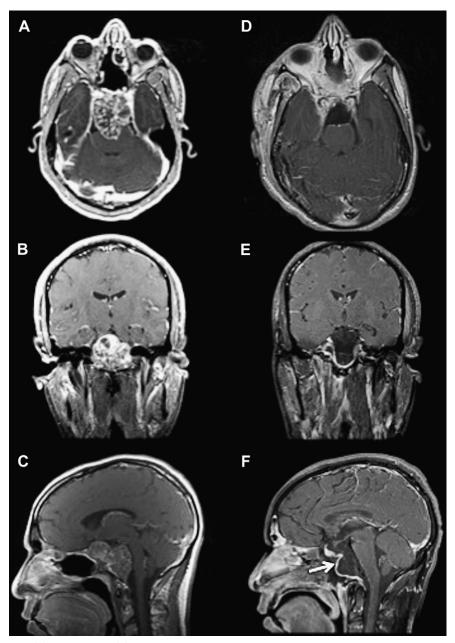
(*A*) Axial, (*B*) coronal, and (*C*) sagittal preoperative magnetic resonance images showing a large recurrent clival chordoma in a 27-year-old male patient. This heterogeneously hyperintense lesion involves the entire clival area, with posterior dislocation of the pons, lateral extension up to both petrous apexes, and invasion of the cavernous sinuses. (*D*) Axial, (*E*) coronal, and (*F*) sagittal postoperative magnetic resonance images after an endoscopic endonasal approach to the clival area, demonstrating the complete removal of the lesion. The arrow shows the enhancing nasoseptal flap that has been used to reconstruct the skull base defect.
